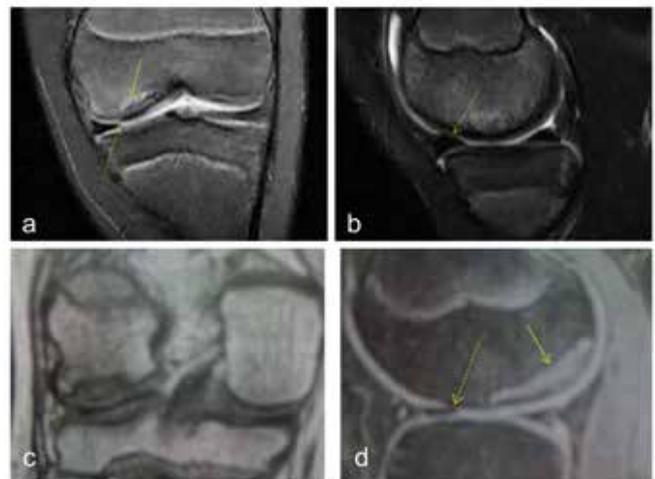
Evaluation of OCD lesion with MRI.
